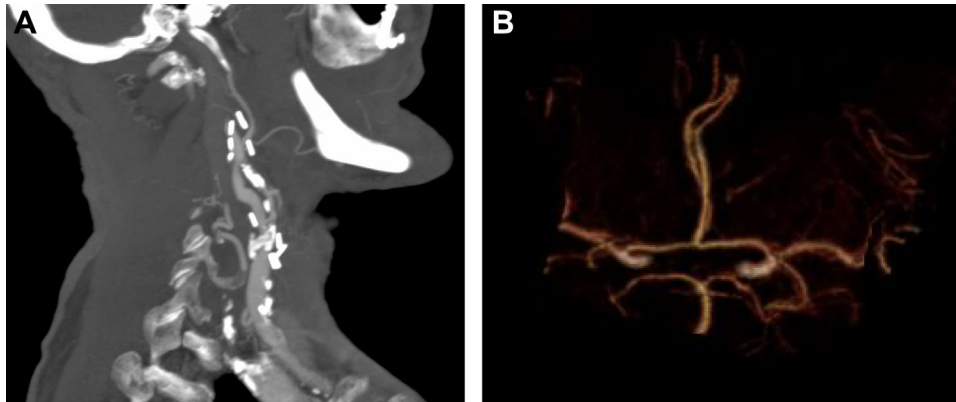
A, Maximum intensity projection of head and neck before transcrotid artery revascularization (TCAR) showing high-grade stenosis of the right internal carotid artery (ICA). B, Three-dimensional reconstructed computed tomography angiography image showing intact circle of Willis.
